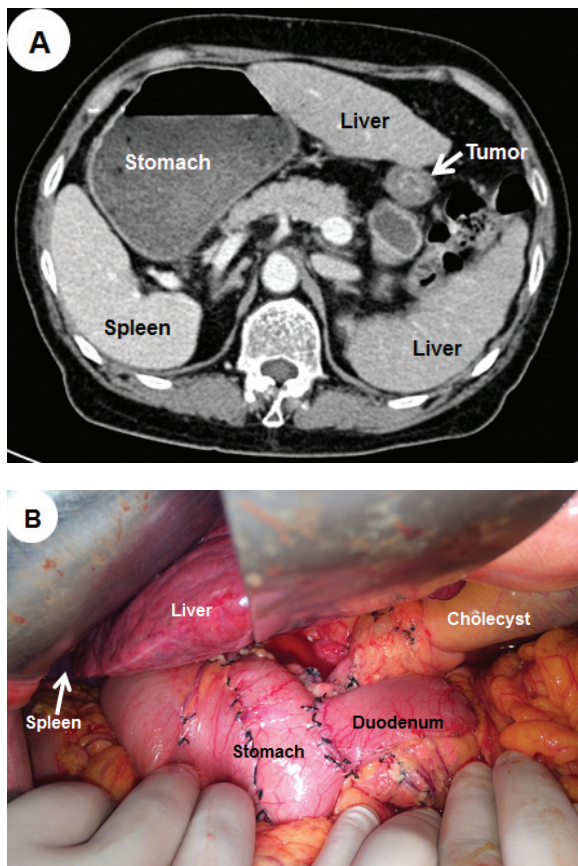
Abdominal computed tomography (CT) and laparotomy revealed situs inversus totalis. A) CT revealed a complete right-left reversal of the abdominal organs and thickened wall of gastric antrum without distant metastasis; B) Laparotomy confirmed the complete mirror-image transposition of the abdominal visceral organs and curative distal gastrectomy with Billroth-I anastomosis was carried out.
